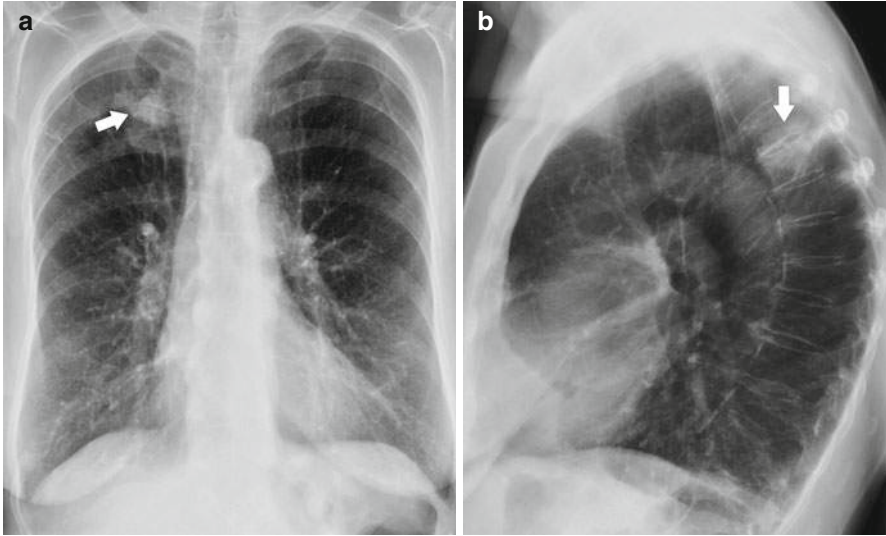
Lung cancer in a patient with emphysema. Chest X-ray posteroanterior (a) and lateral (b) views show a 3-cm mass in the right upper lobe (arrows)
